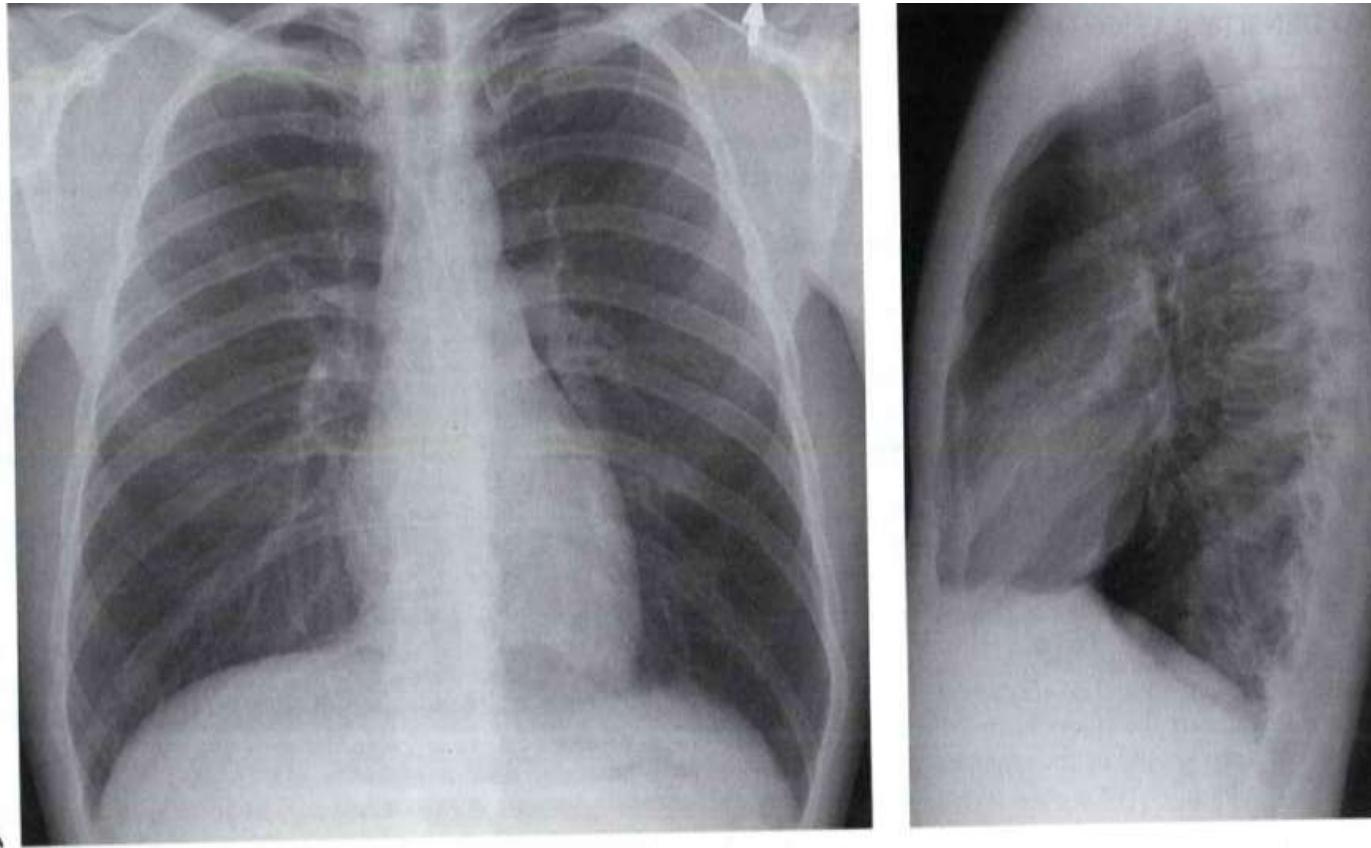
Normal PA (A) and lateral (B) chest radiographs, showing the structures numbered and labeled in Figure 1-1.
